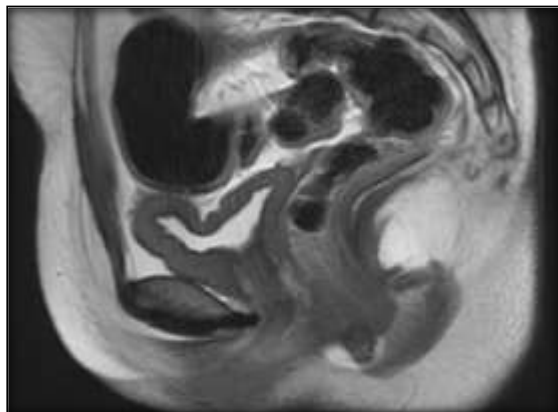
MRI images showing absence of uterus and upper part of vagina suggestive of complete agenesis of uterus and 2/3rd of vagina however both ovaries were normal
